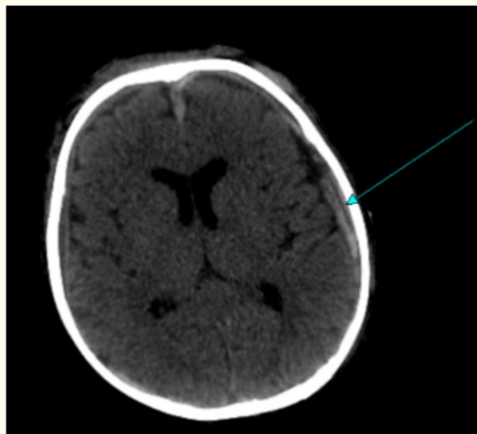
A computed tomography (CT) scan of the skull revealed a chronic subdural hematoma in the left hemisphere (indicated by the arrow).
